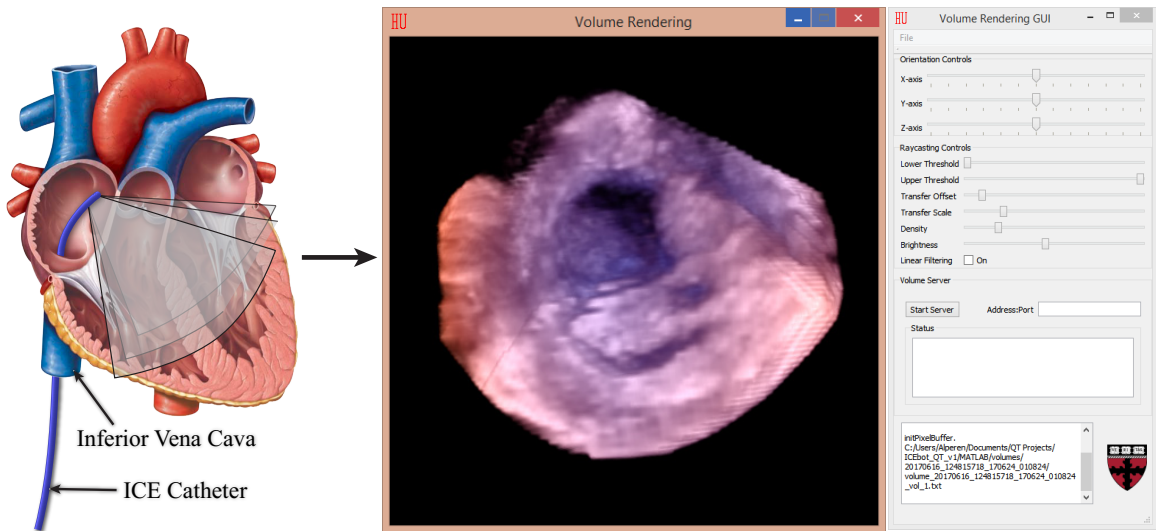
The volume rendering graphical user interface enables real-time user interaction with a 4D (3D + time) ultrasound image of the anatomy. The ultrasound volume is reconstructed from a series of 2D ultrasound images that are acquired at different imaging angles throughout the cardiac cycle.*
